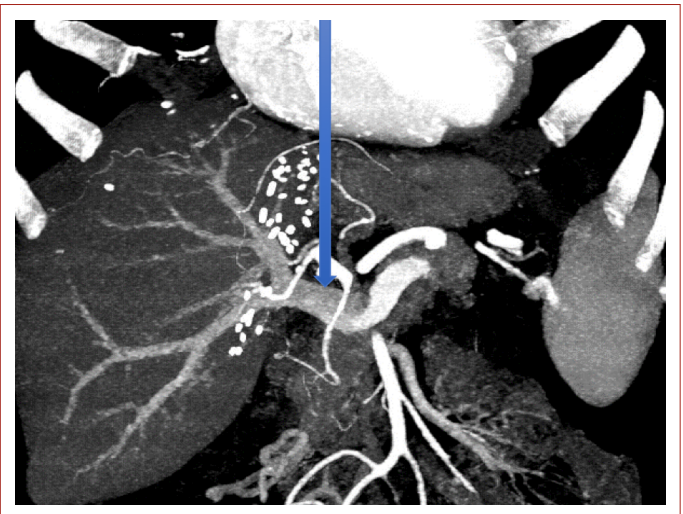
Dynamic CT (portal phase) performed 11 months post-transplant showing patent portal reconstruction.
